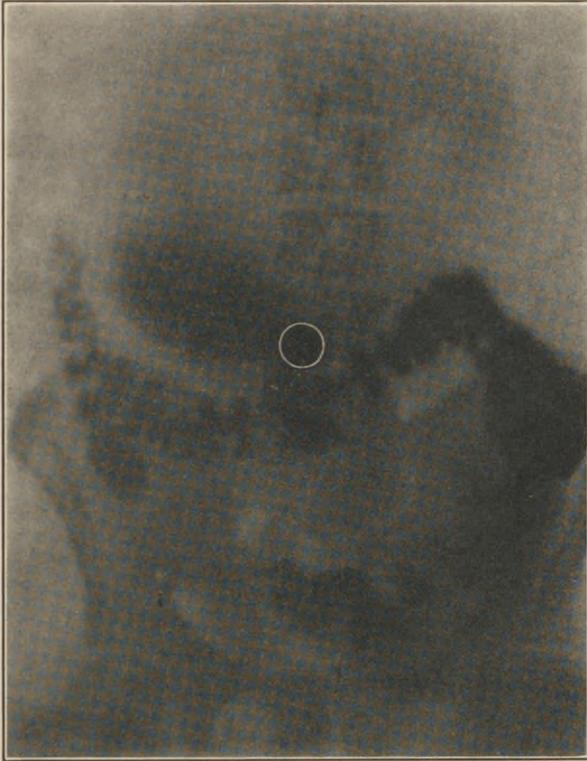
X-RAY PICTURE OF SAME SUBJECT AS SHOWN IN FIG. 138, TAKEN SIX HOURS AFTER BISMUTH MEAL.
